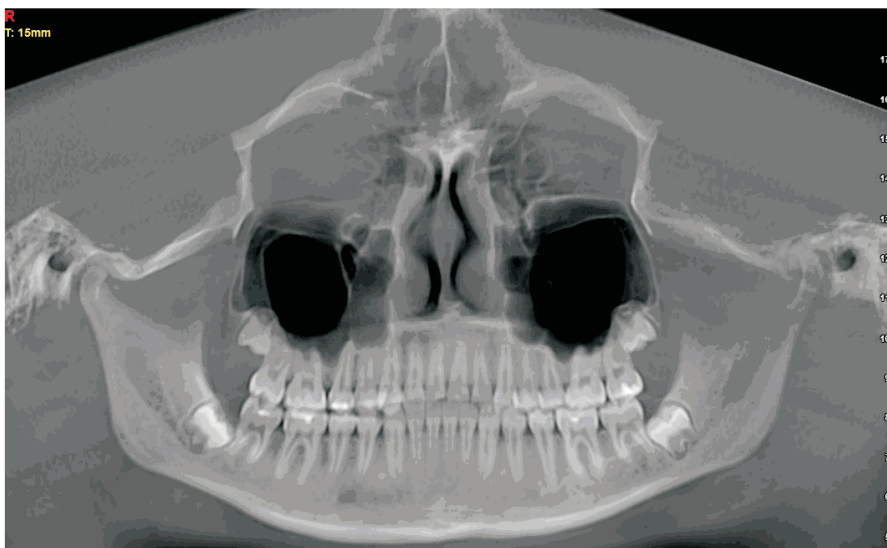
Panoramic radiograph reconstructed from 3D imaging, covering the entire facial skeleton.
